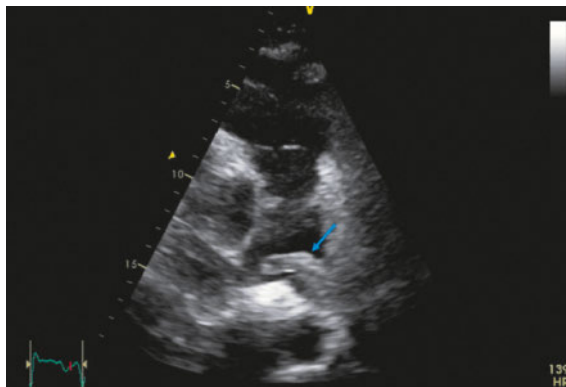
Modified parasternal short axis view with focus on the pulmonary artery. A large embolus (arrow) occluding the left pulmonary artery and protruding in right pulmonary artery is depicted in a patient with acute pulmonary embolism.
